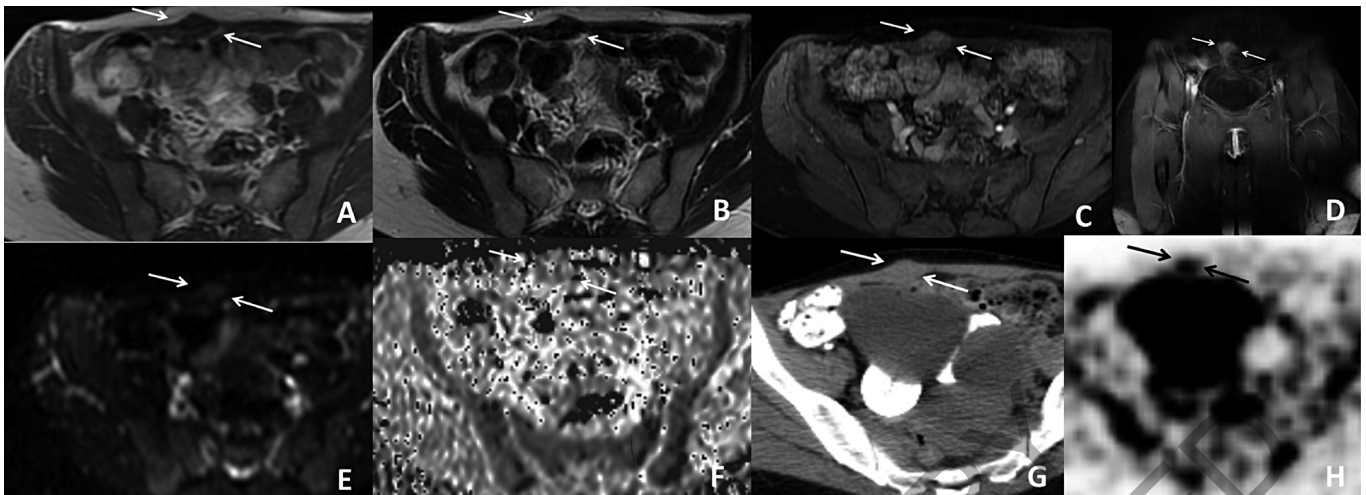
35-year-old patient presented with complaints of abdominal pain. On T1 weighted image a 21x11x17 mm isointense mass is located at right rectus abdominis muscle (arrows) (A). Mass is hypointense on the T2 weighted image and markedly enhances on contrast enhanced fat saturated axial and coronal T1 weighted image (arrows) (B, C, D). Mass is hyperintense on diffusion weighted images, and hypointense on ADC map compatible with restricted diffusion (arrows) (E, F). On 18- FDG-PET CT images, mass is isodense and shows mild FDG uptake (SUVmax=1.6) (arrows) (G, H).
